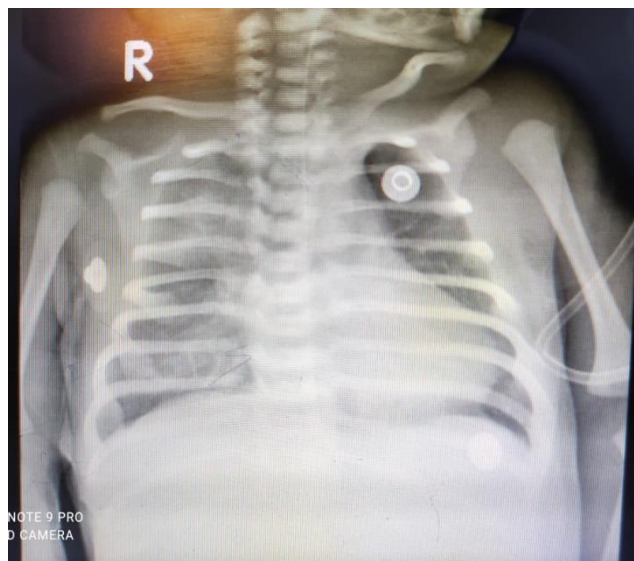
The image presents the patient's chest X-ray.
